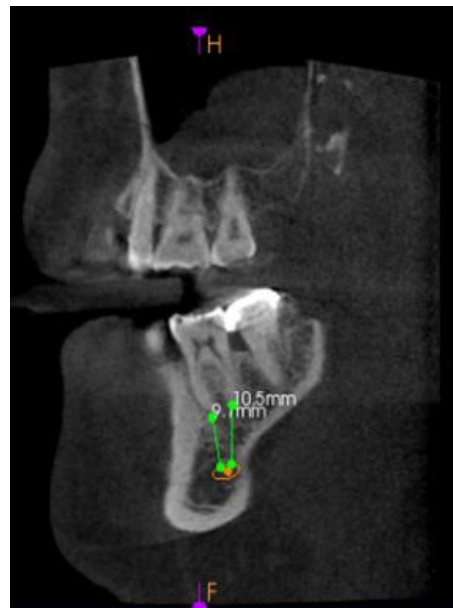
Examples of the measurements taken for both the mesial and distal roots of the mandibular first molar on (Sagittal View) CBCT Scan.
